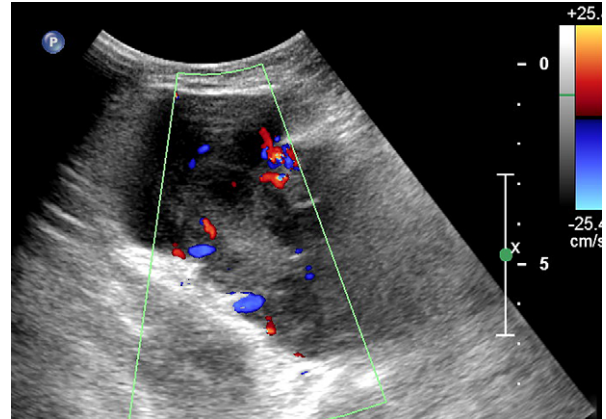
Venous ultrasound of the lower extremity reveals an irregular, large, heterogeneous mass with areas of necrosis at the confluence of the superficial and the profunda femoris veins. The mass demonstrates abnormal high vascularity on colour Doppler. The femoral vessels cannot be identified discretely at this level.
